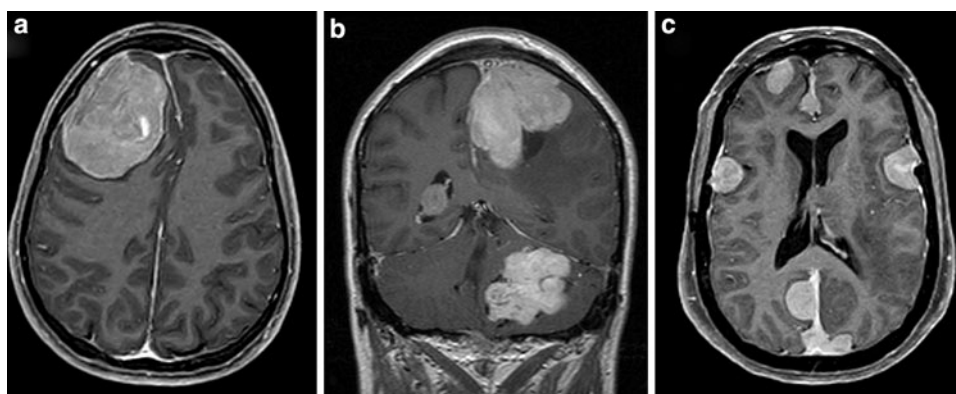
T1-weighted MRI with Gadolinium enhancement showing aspects of cranial meningiomas in NF2 patients. a right frontal convexity meningioma responsible for intra cranial hypertension (b) coronal view showing the association of a large left parasagittal
